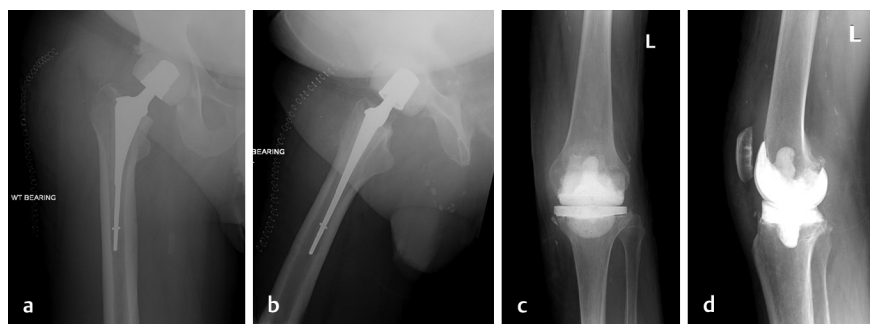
Radiographic examples of both a hip (a, b) and knee (c, d) articulating spacer implanted after explantation for periprosthetic joint infection during two-stage exchange arthroplasty.
